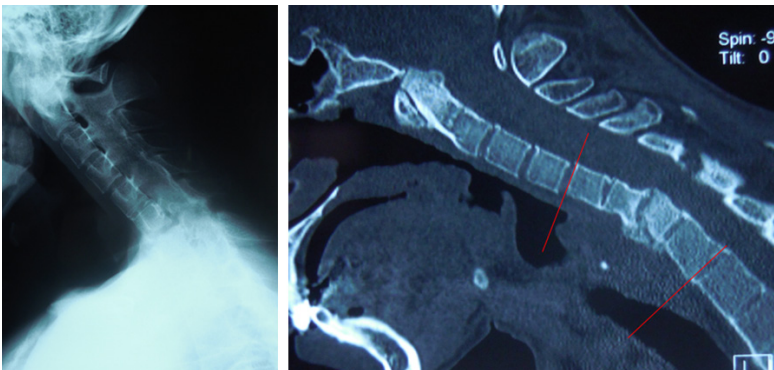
Lateral X-ray and CT scan demonstrated cervicothoracic kyphotic deformity with C5-T1 Cobb angle of 54° and Anderson lesion (AL) within C6-7 disc space.
